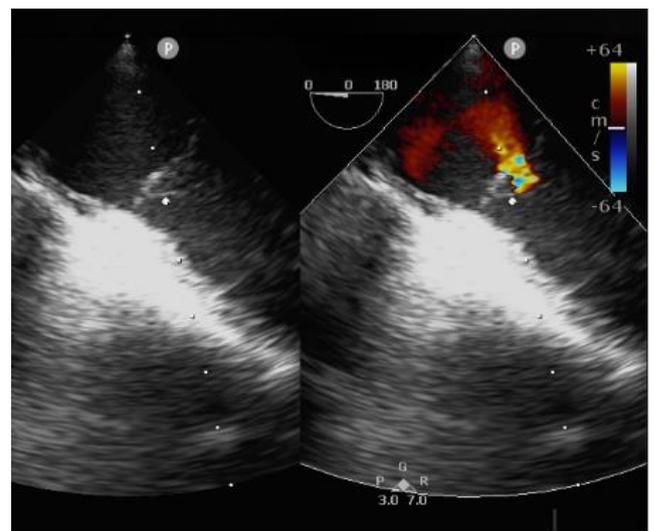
Transesophageal echocardiography indicates mild tricuspid regurgitation during orthosis reversal.
